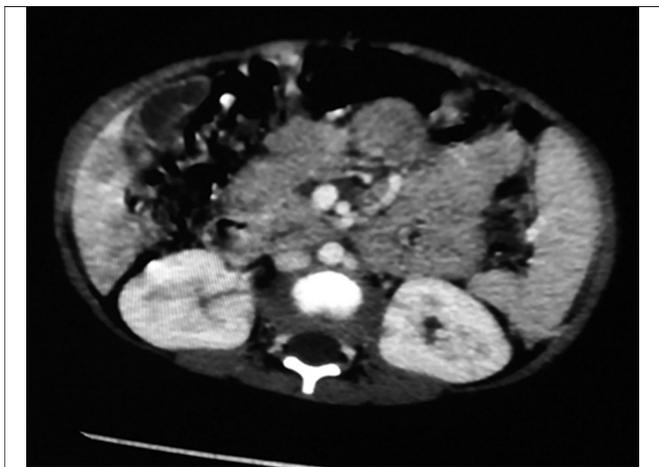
Computed tomography scan abdomen with contrast showing enlarged liver studded with multiple ill-defined hypodense focal lesions.
